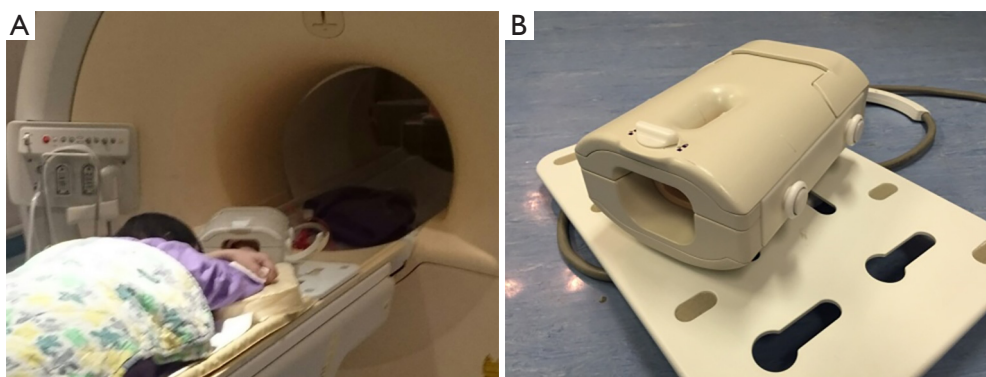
Real time situation when the patient is undergoing MRI examination of the wrist within the MRI scanner. (A) In the MRI scanner, the patient lies prone with the hand above the head in a “superman” position. Superman position allows the wrist to be scanned in the isocenter of the magnetic field, which is more homogeneous. The wrist in this position is slightly semipronated; (B) a dedicated wrist coil achieves a high resolution and signal to noise ratio. Motion artefact is the most commonly encountered problem during wrist imaging as the patient needs to maintain still for approximately 20–30 minutes in prone and superman position.
